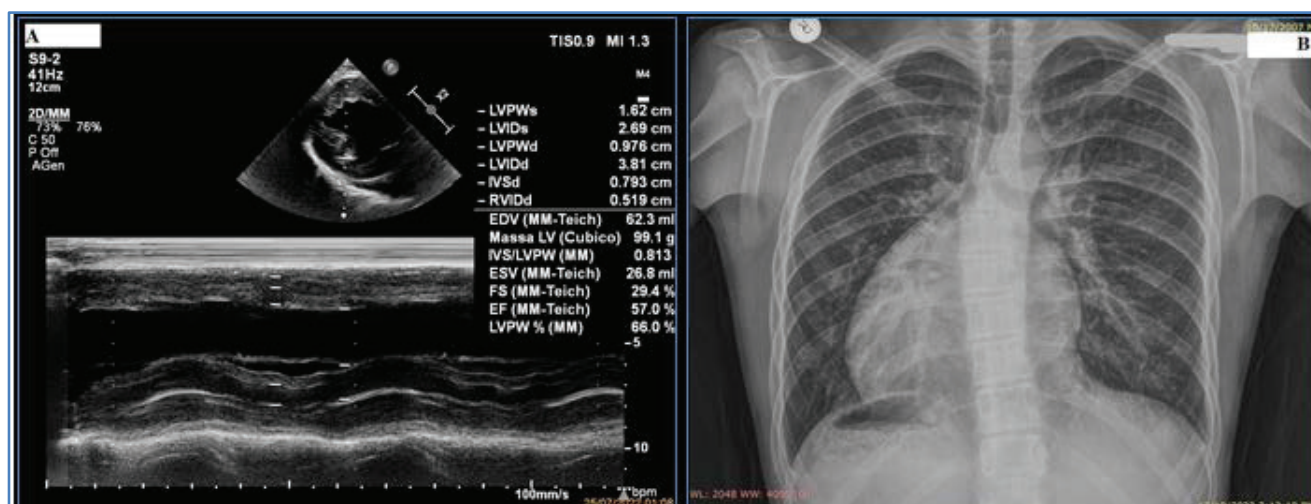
(A. echocardiography on 25/07/2022; B. Chest x-ray on 19/12/2023)
